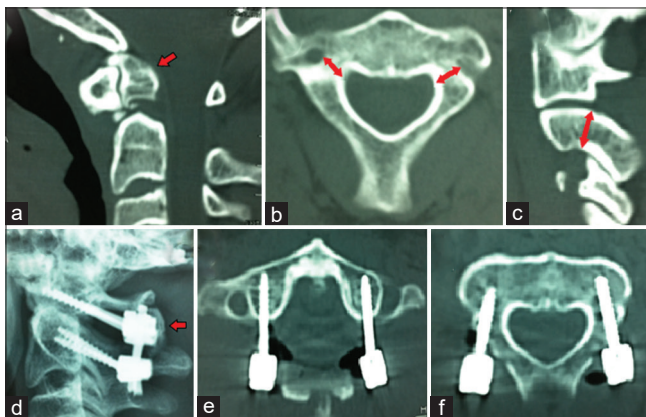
Imaging from case 15; male of 26 years old with Os odontoideum. (a) Sagittal computed tomography; the arrow shows the free well-corticated ossicle. (b) Axial computed tomography passing through C2; the arrows show laterally wide pedicles. (c) Parasagittal computed tomography; the arrow shows the superior to the inferior wide pedicle. (d) Postoperative lateral X-rays; showing C1-C2 fixation, the arrow is pointing to the graft placement. (e and f) Axial computed tomography passing through atlas and axis
